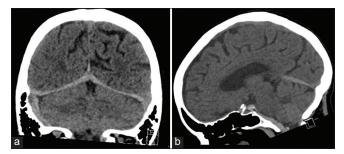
Computed tomography (CT) without contrast of the head at initial presentation. (a) Coronal image with bilateral subdural hematoma (SDH) inferior to the tentorium with more blood product being on the right side. (b) Sagittal image with SDH inferior to the tentorium and dorsal to the clivus with extension into the ventral cervical spine.
